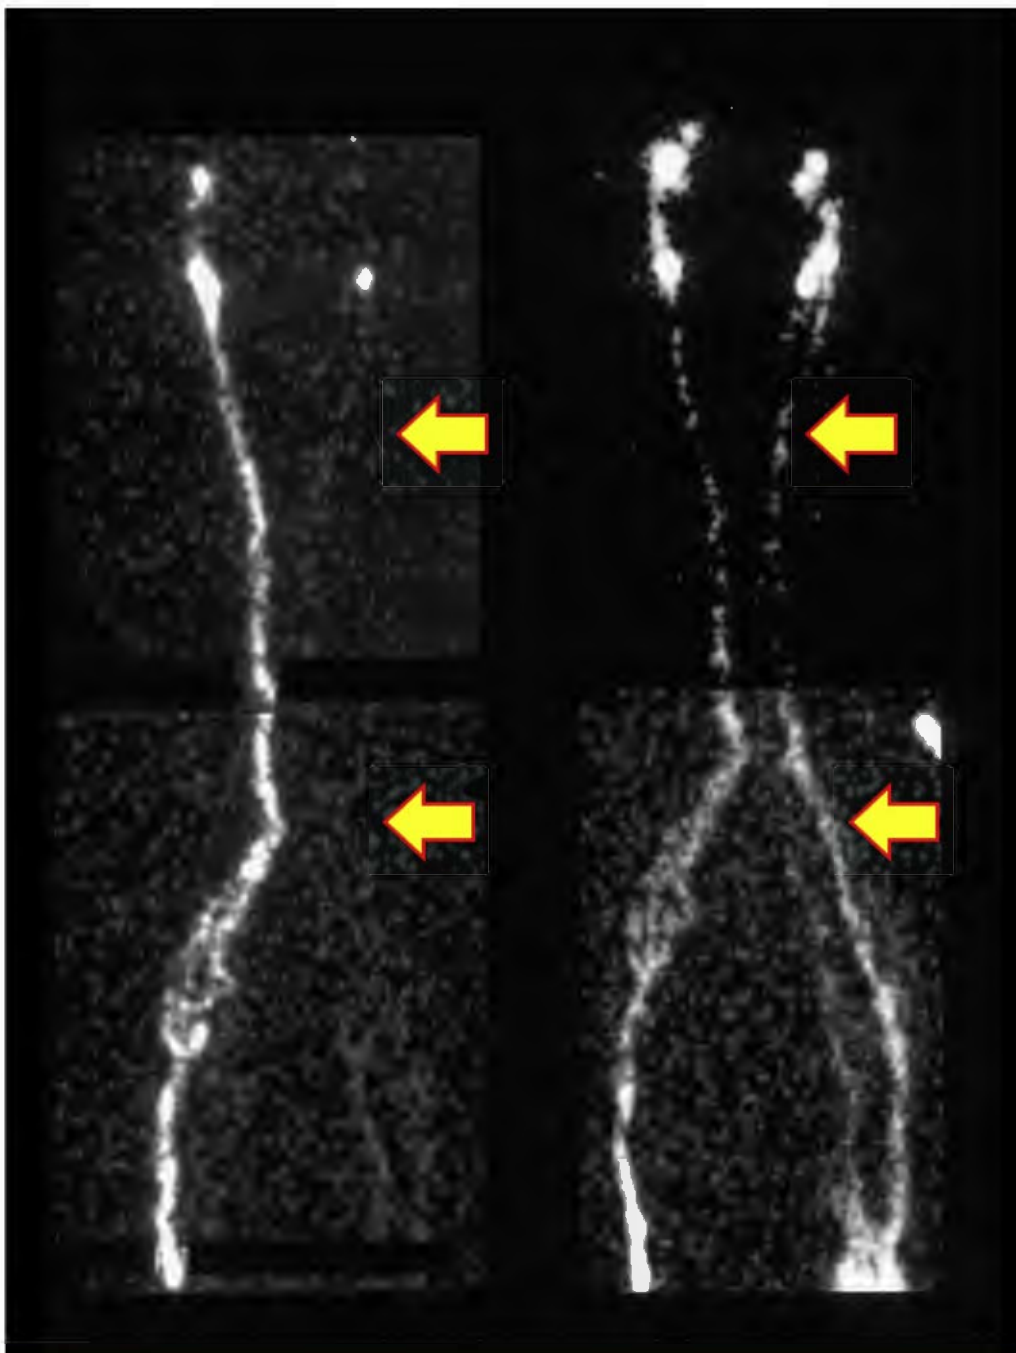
Lymphoscintigram demonstrating recovery of lymphatic function after correction of ilio caval obstruction. Uptake in the lymphatic channels and lymph nodes not seen on the *left* is now seen on the *right*.
